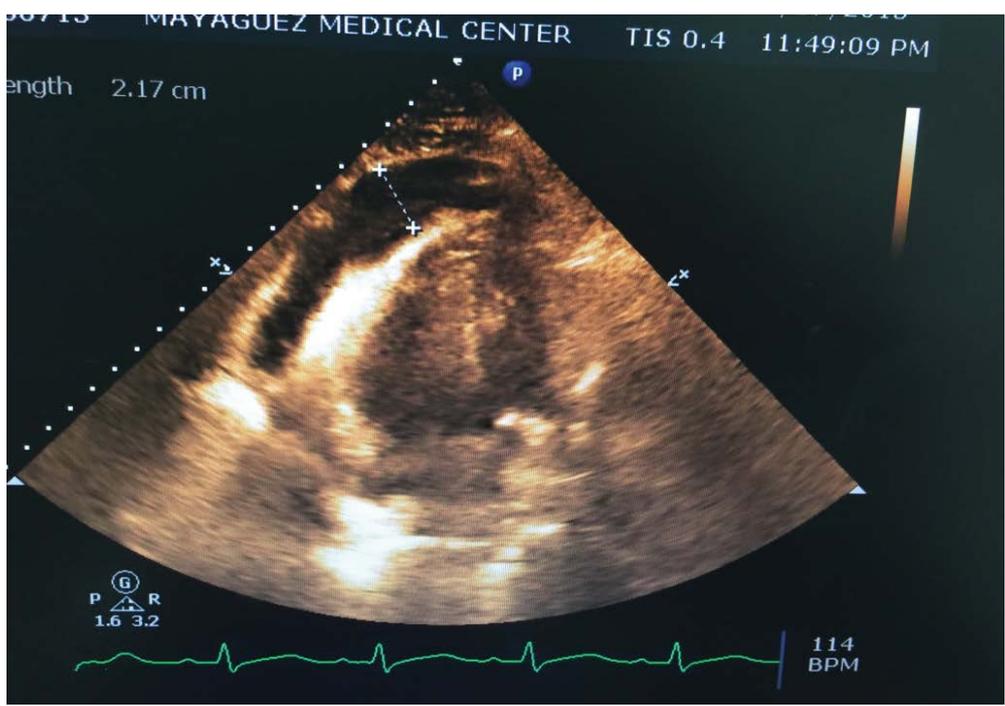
Echocardiography: cardiac tamponade physiology.
